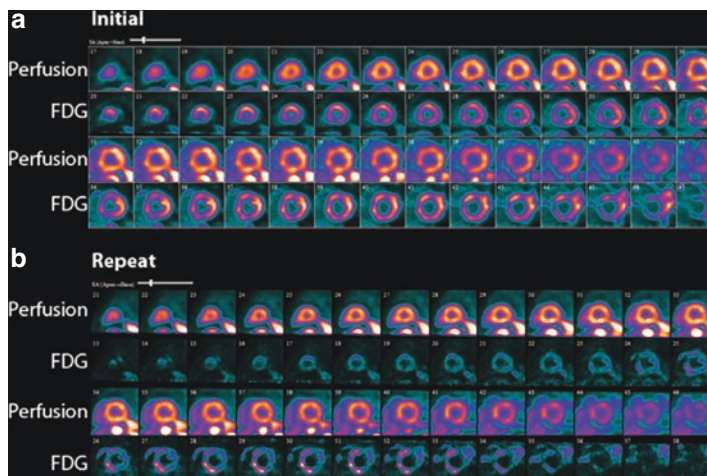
Limited dietary preparation for FDG PET (a) which improved on repeat imaging (b). An example of perfusion and FDG images showing diffuse FDG uptake in normally perfused segments suggesting incomplete suppression of physiological uptake (a) Repeat images after 3 months (b) using a more stringent carbohydrate restriction and increase intake of high fat diet followed by 12 h fast prior to FDG imaging demonstrated better suppression of physiological myocardial glucose uptake. *FDG* ^{18}F -fluorodeoxyglucose
